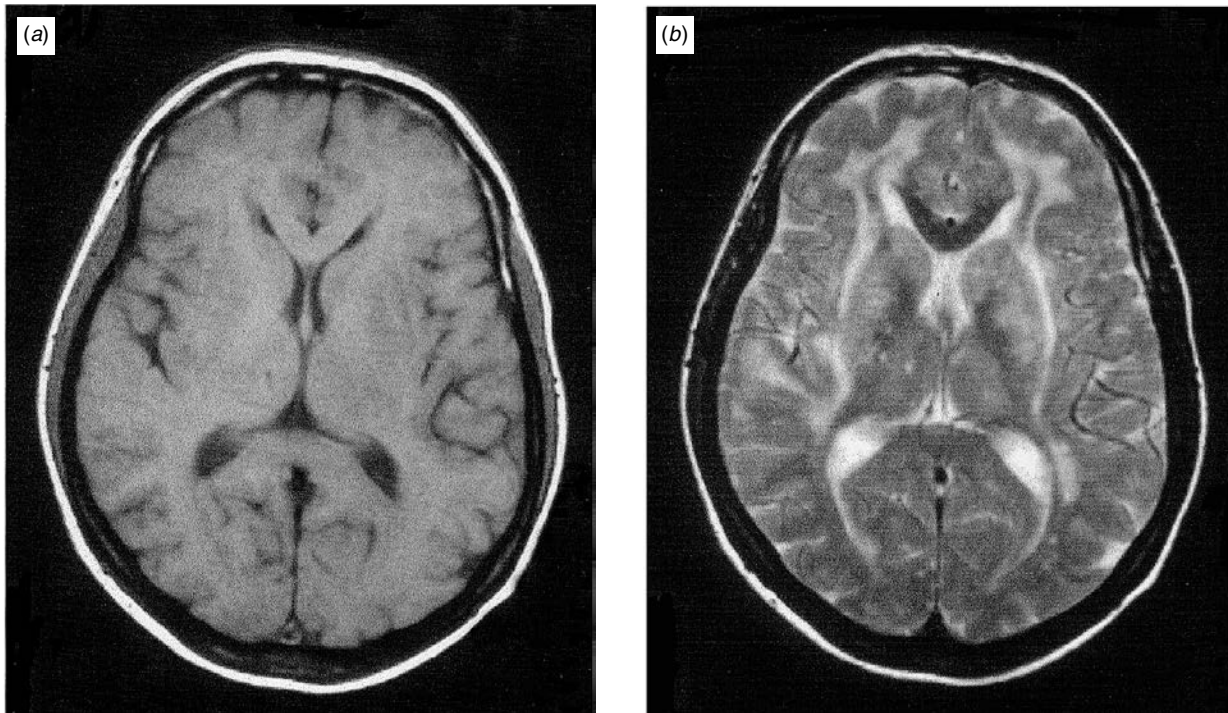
Magnetic resonance images of a 48-year-old patient with CADASIL. (a) T_1 -weighted image showing a small circumscribed lesion within the right thalamus as well as periventricular signal hypointensities; (b) T_2 -weighted image showing diffuse signal-hyperintensities in the periventricular white matter and the external capsule.
